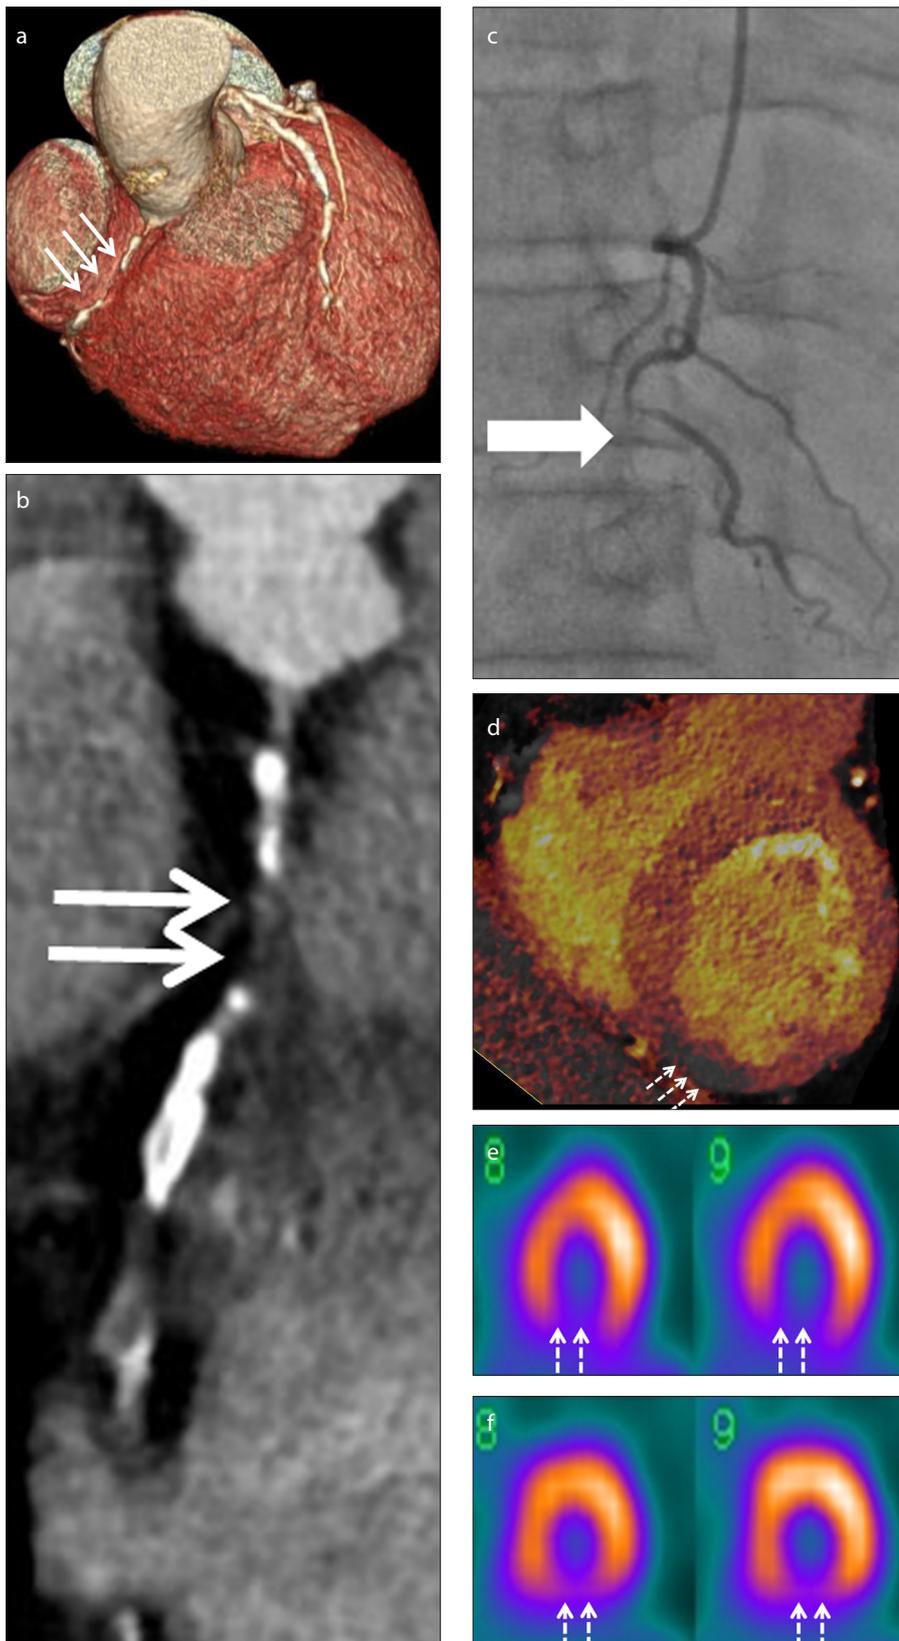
a–f. Reversible perfusion defect in RCA territory in a 52-year-old male CAD patient. Volume-rendered (a) and curved multiplanar reformatted (b) DECT coronary angiography images show area of non-opacification of RCA (arrows). ICA (c) shows complete occlusion of RCA (bold arrow). DECT perfusion short axis view (d) shows perfusion defect in inferior left ventricular myocardium in RCA territory (dashed arrows). Short axis view of stress (e) and rest (f) SPECT reveals reversible ischemia (dashed arrows) in inferior and adjacent infero-septal segments (RCA territory).
